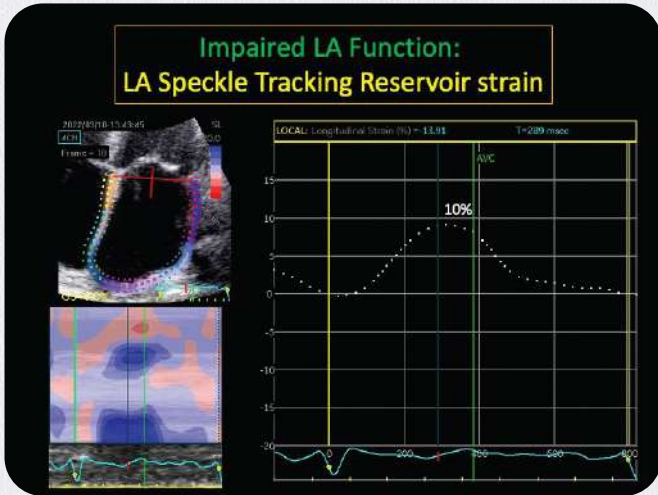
Speckle tracking echocardiography shows severely impaired Left atrial (LA) reservoir strain (10%). The amyloid deposition in the thin LA myocardium causes LA electro-mechanical dysfunction and high incidence of clot formation.
